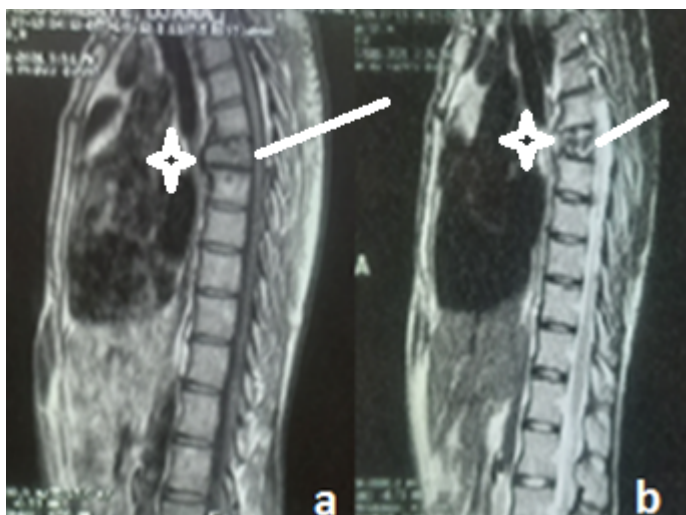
MRI of the dorsal spine showing an expansive lesion centered on the body of T6 with multiple cystic pockets more lateralized on the left and significant thinning of the cortex without clear rupture.
